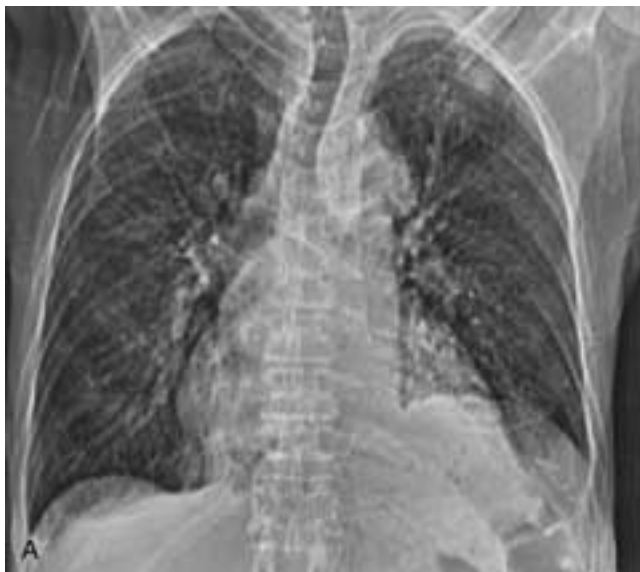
Lung carcinoma. CT scout scan (*A*) shows elevation of the left hemidiaphragm. Axial CT scan (*B*) demonstrates a large, inhomogeneous mass in the left side of the neck. This mass is encasing the scalene muscles, resulting in phrenic nerve palsy and brachial plexopathy.
